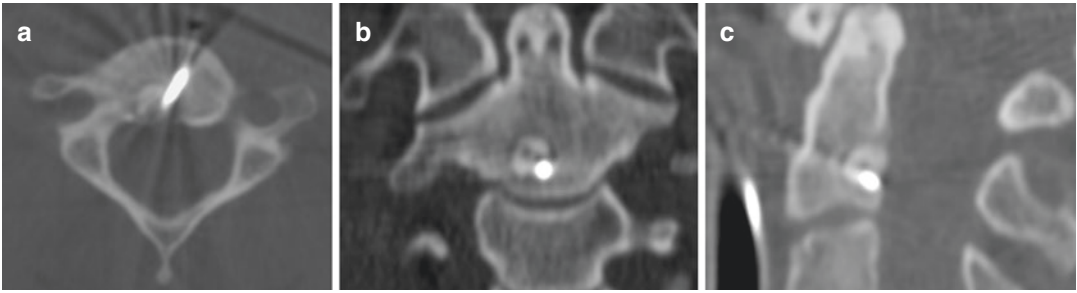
Osteoid osteoma localized in the second cervical vertebra; CT multiplanar reconstruction (a axial, b coronal, c sagittal) allowed precise RF probe positioning within the lesion by means of a trans-oral approach
